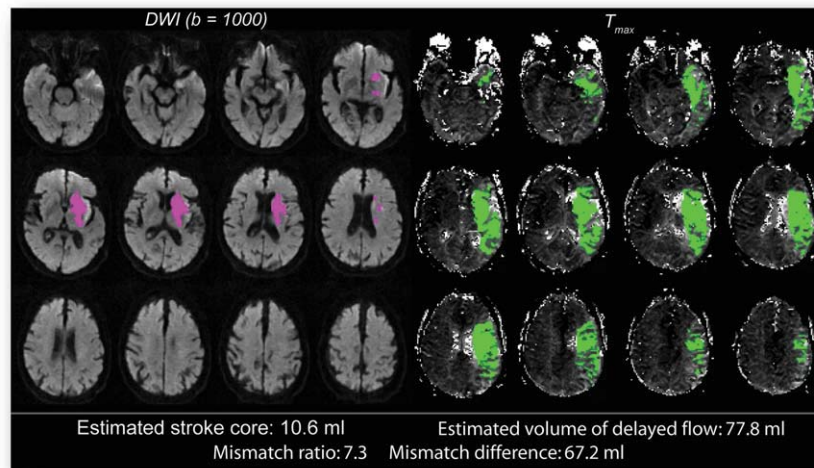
Automatic assessment of DWI/PWI mismatch with RAPID in an acute stroke patient. (Left side) $S_{b=1000}$ images overlaid with stroke core identified using ADC threshold. (Right side) T_{max} maps with green overlay for regions with abnormal flow ($T_{max} > 6$ s). (Bottom) DWI lesion volume, PWI lesion volume, their ratio, and absolute difference is presented. This entire panel is presented automatically to the clinical readers by means of PACS, scanner console, email, and smartphones to facilitate mismatch-based patient triage.
